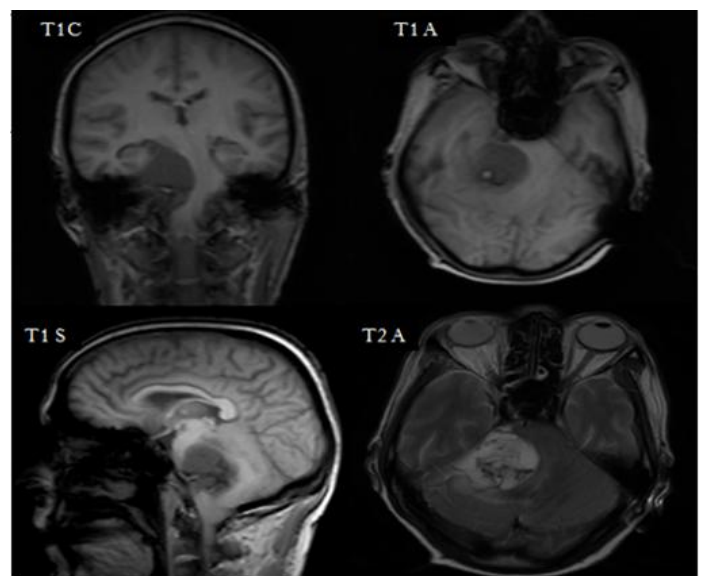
MRI T1W and T2W images showing heterogeneous intensity lesion at right CP angle suggestive of CP angle schwannoma
